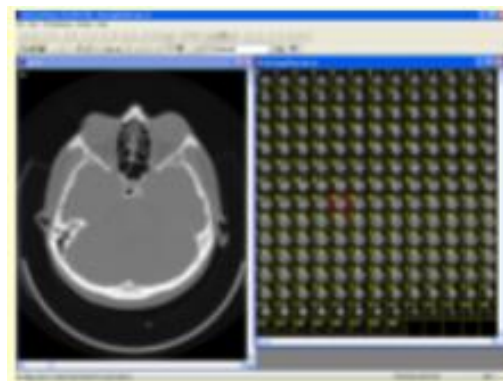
CT-Slice images
